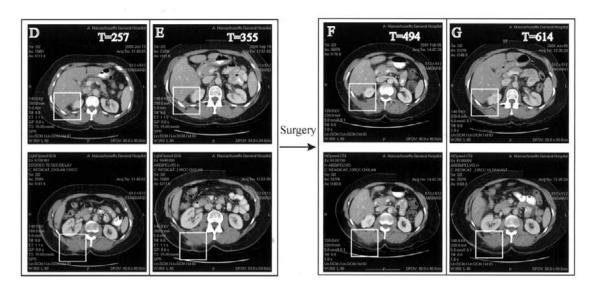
Abdominal CTs from patient 1 that demonstrate serial abscesses over time. The top panels in the series are CT images in which the perihepatic collection can be best visualized, and the bottom panels reveal the soft-tissue fluid collection. The white box indicates the site of abscess for both locations. Each CT is labeled with the indicated time (T; in days) from initial presentation to the hospital. The patient underwent percutaneous drainage in the time between what is represented by panels *A* and *B* and underwent surgical excision of the tract, remaining gallstones, and the abscess between the times represented by panels *E* and *F*.
